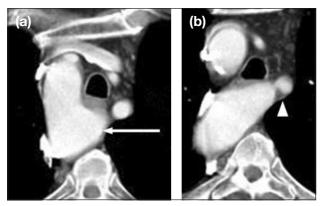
Computed tomography scan of the chest demonstrates (a) a right-sided aortic arch and Kommerell's diverticulum (arrows) at the origin of an aberrant left subclavian artery; and (b) focal luminal narrowing is noted at the origin of the left subclavian artery (arrowhead).
